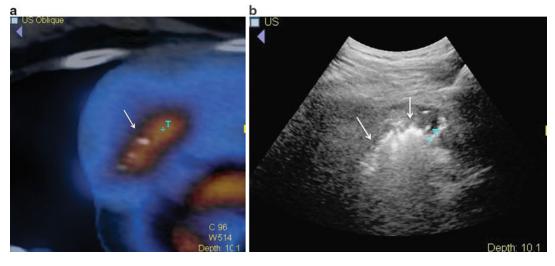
(a) Fused imaging (Philips Percunav system) overlay of a positive octreotide SPECT scan with an ultrasound image to visualize a neuroendocrine tumor (*arrow*) liver metastasis that was not visible on ultrasound
